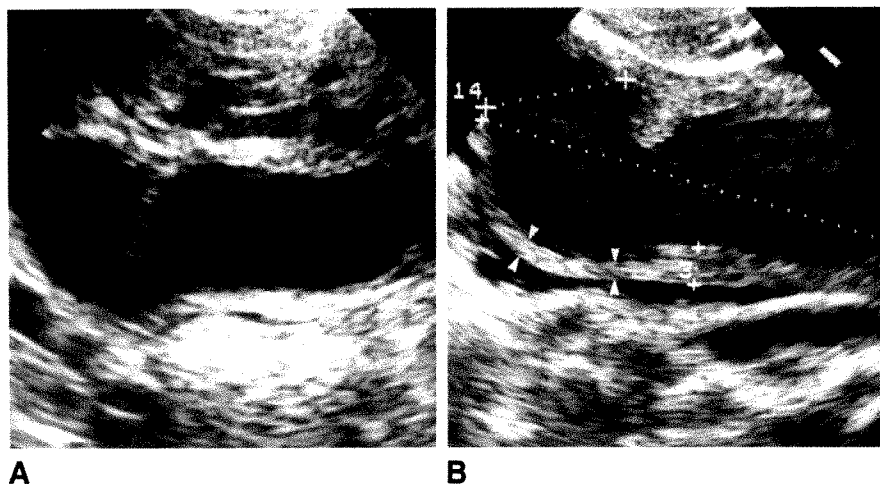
A, Sagittal endovaginal sonogram of left adnexal region shows a 1.6-cm tubular structure characteristic of a dilated fallopian tube, which proved to be pyosalpinx at surgery.
